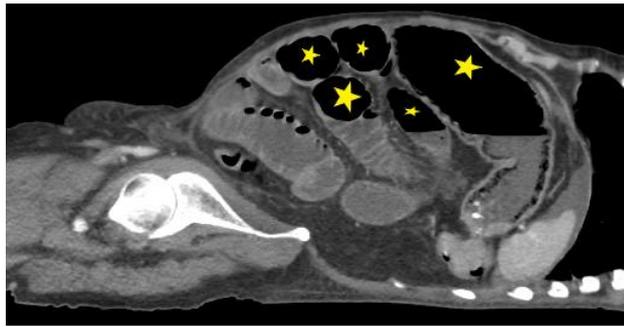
On the sagittal view of computed tomography, there were multiple air-fluid levels (yellow asterisks)
